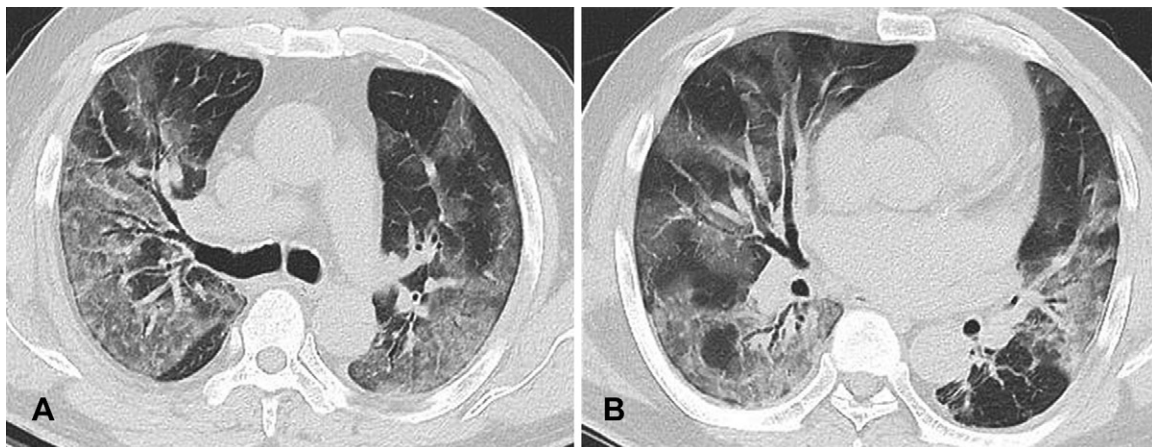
COVID-19 pneumonia with diffuse alveolar damage pattern in a 64-year-old unvaccinated man with no underlying disease at Delta variant-dominant period. (A, B) Follow-up transverse nonenhanced CT scans (lung window) obtained at levels of right main bronchus (A) and right middle lobar bronchus (B) 1 day after positive nucleic acid amplification test for COVID-19 demonstrate extensive areas of ground-glass opacity involving bilateral lungs.
